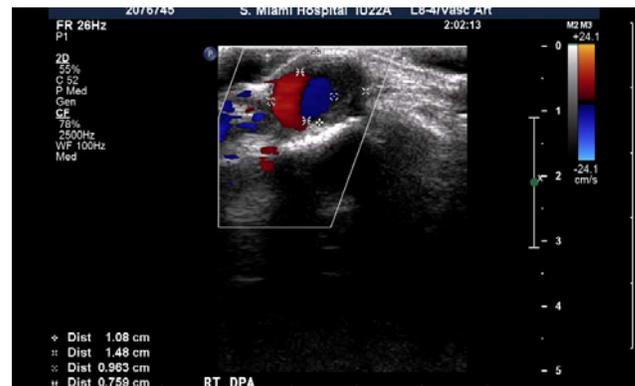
Colorflow Duplex Ultrasound (CFDUS) imaging reveals dorsalis pedis aneurysm with thrombus formation noted within the artery.
